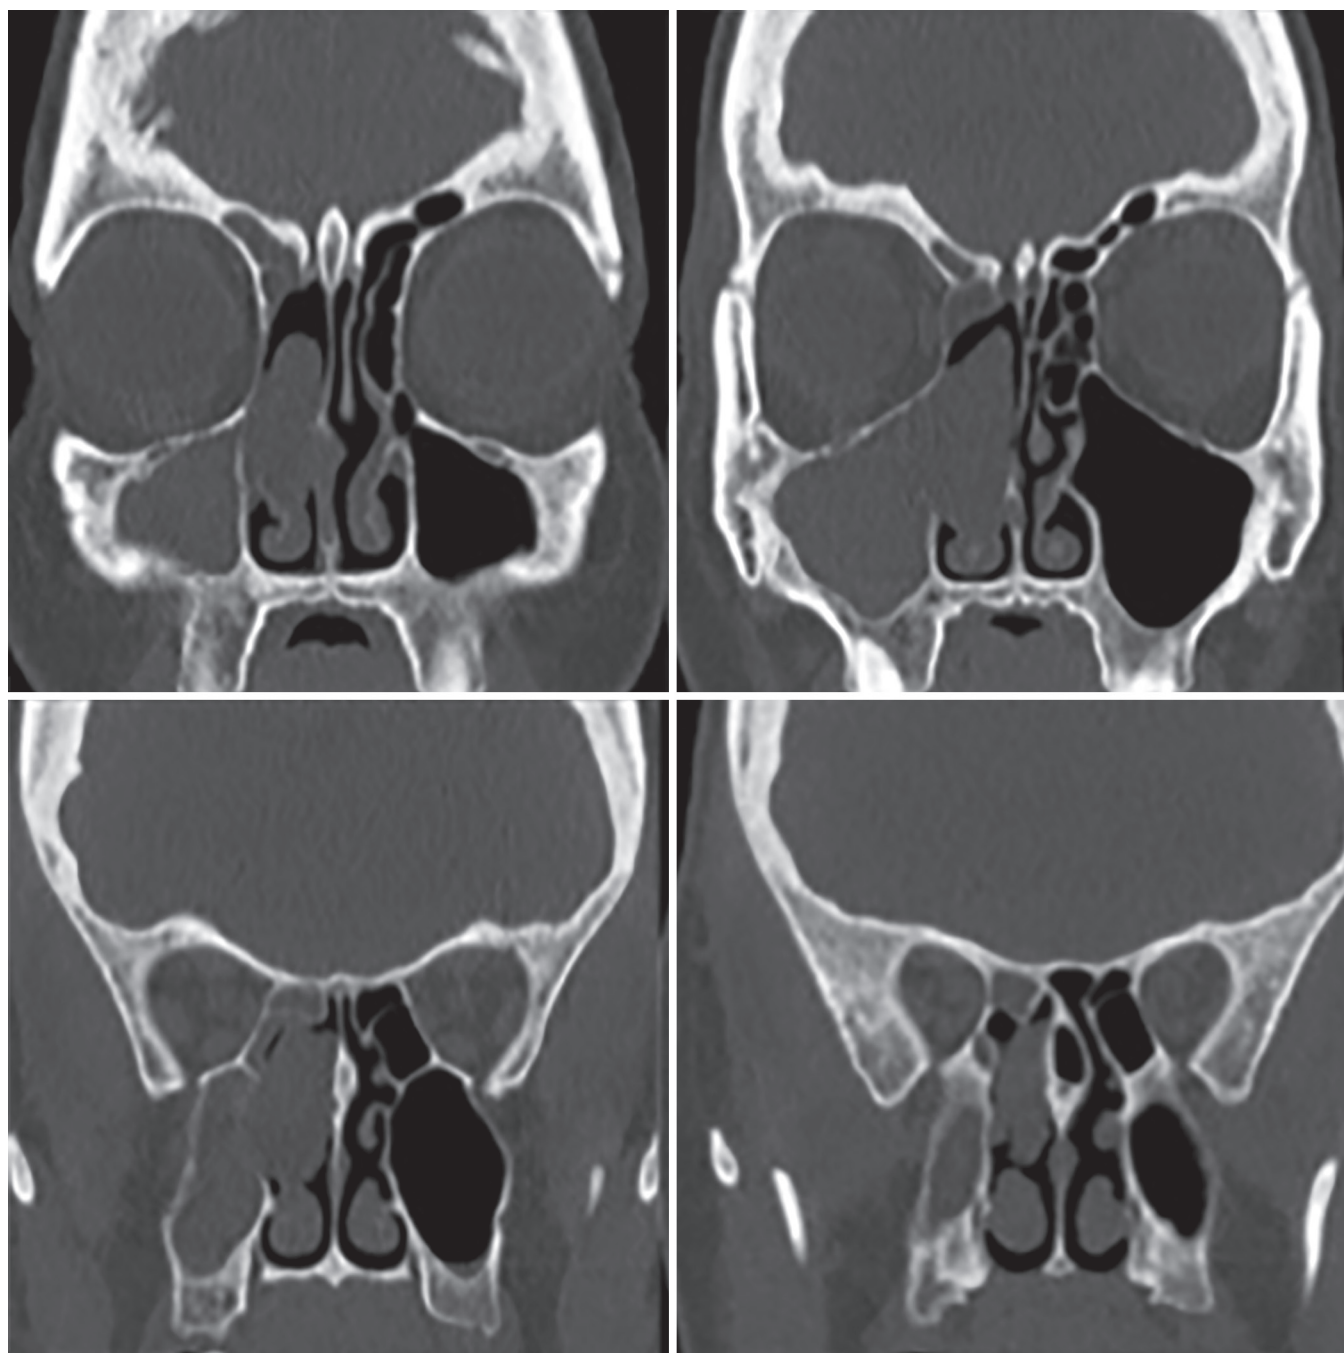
Computed tomographic imaging of a patient with a right-sided respiratory epithelial adenomatoid hamartoma.
